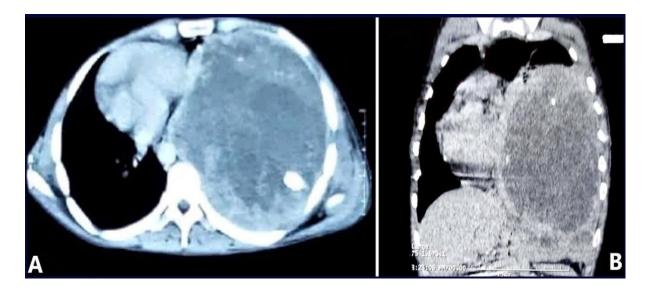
CT Thorax (A, axial view & B, coronal view) showing large mixed solid cystic mass lesion with small calcified foci occupying $2/3^{rd}$ of left hemithorax with displaced mediastinum to right side.
